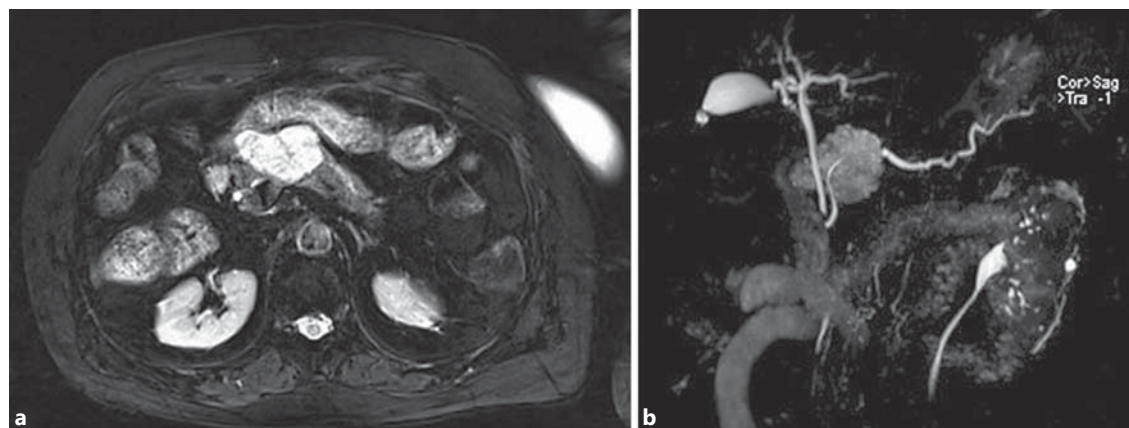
Magnetic resonance cholangiopancreatography (MRCP): 45-mm hypervascular moderately hyperintense mass in the pancreatic isthmus, with intermediate-high signal intensity on T2-weighted imaging, suggesting a complex solid microcystic lesion (a, axial T2-weighted imaging; b, MRCP).
